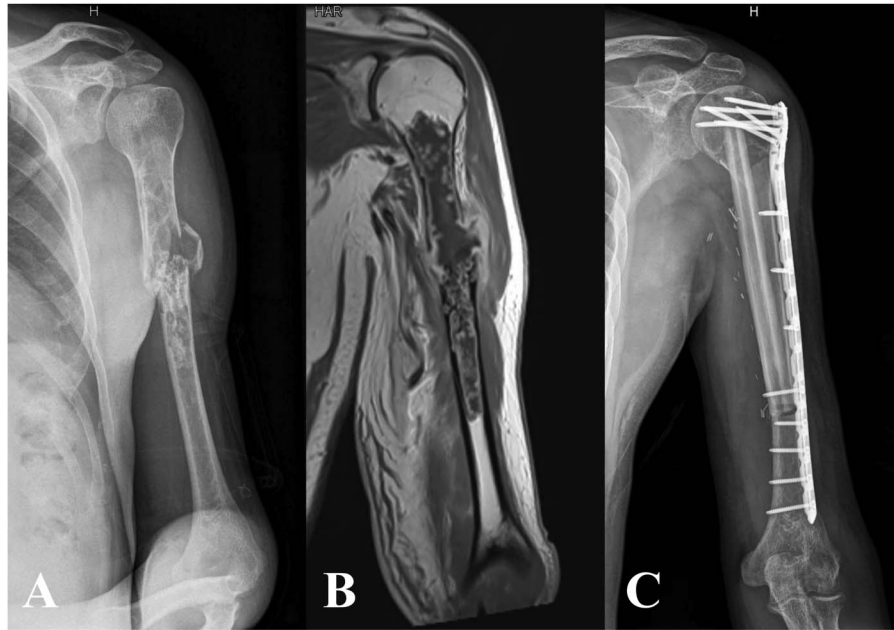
(A) This is a radiograph of a 51-year-old man with pathologic fracture of the humeral diaphysis because of Grade 2 chondrosarcoma. (B) A coronal T1-weighted MR image with contrast shows proximal metaphyseal extension of the tumor to the neck of the humerus. (C) This postoperative radiograph shows reconstruction with VFG combined with a massive allograft and bridging plate to achieve more stable proximal fixation.
